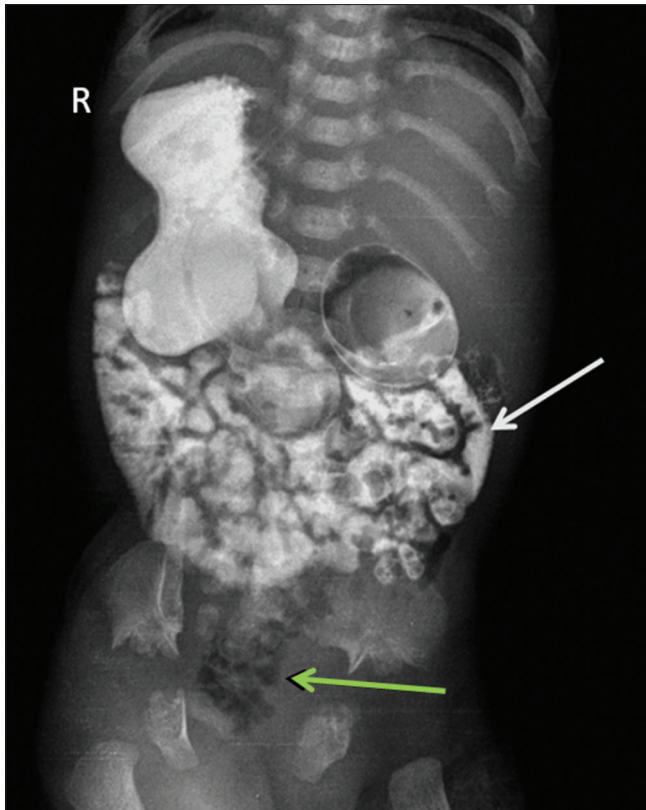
Upper gastrointestinal contrast radiograph obtained at 5 h shows delayed gastric emptying. The duodenal loop (*white arrow*) is seen in a mirror configuration. Opacified jejunal loops are seen on the right side of the abdomen. Air-filled large bowel is seen in the midline of the abdomen (*green arrow*)
